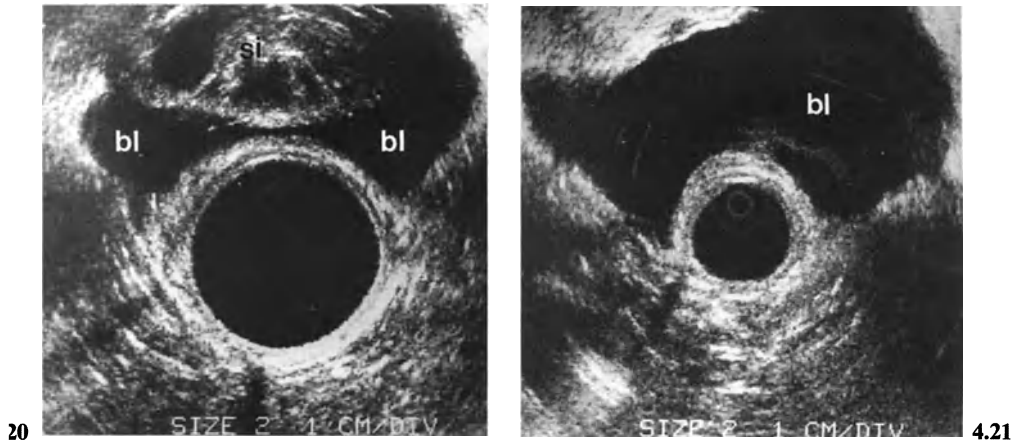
Sonogram of the bladder (*bl*), partially filled with urine. The bladder wall is distorted by a loop of small intestine (*si*)
